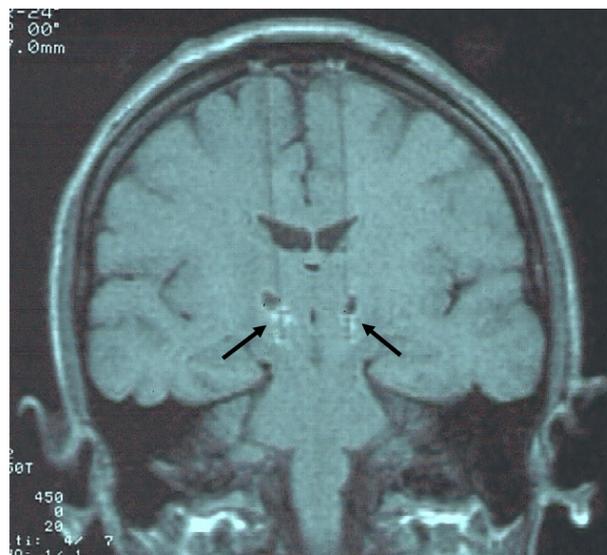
T2-weighted magnetic resonance imaging coronal view following external stimulation. Lesions in each subthalamic nucleus areas (black arrows) are consistent with bilateral subthalamotomy.
